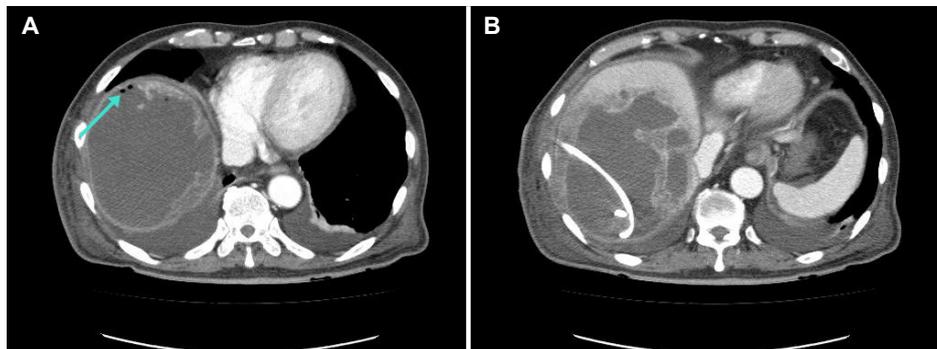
Computed tomography (CT) scan of the abdomen. (A, B) On hospital day 6, the CT scan showed air bubbles (arrow of A) and a decrease in abscess size.
